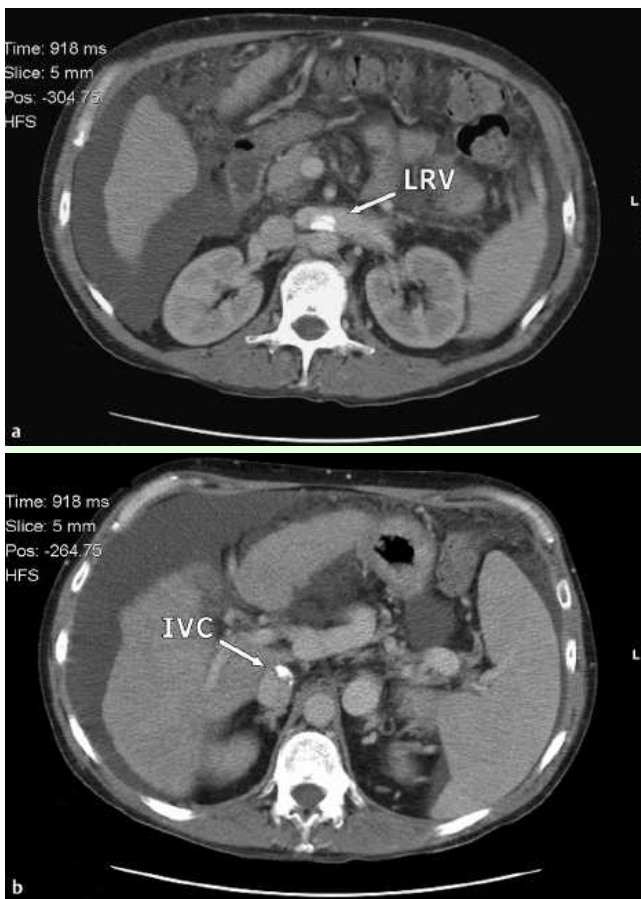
a, b Abdominal CT scan demonstrating the persistence of the multifocal radiopaque densities in the inferior vena cava (IVC) extending to the left renal vein (LRV) at 24 weeks after glue injection therapy.
